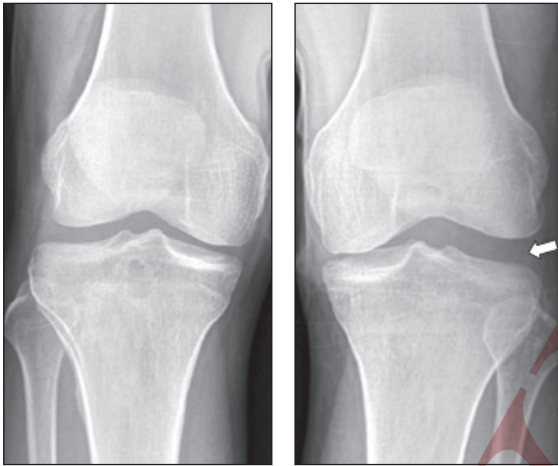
X-ray with varus loading showing increased lateral joint space widening, indicated by an arrow in the injured knee
